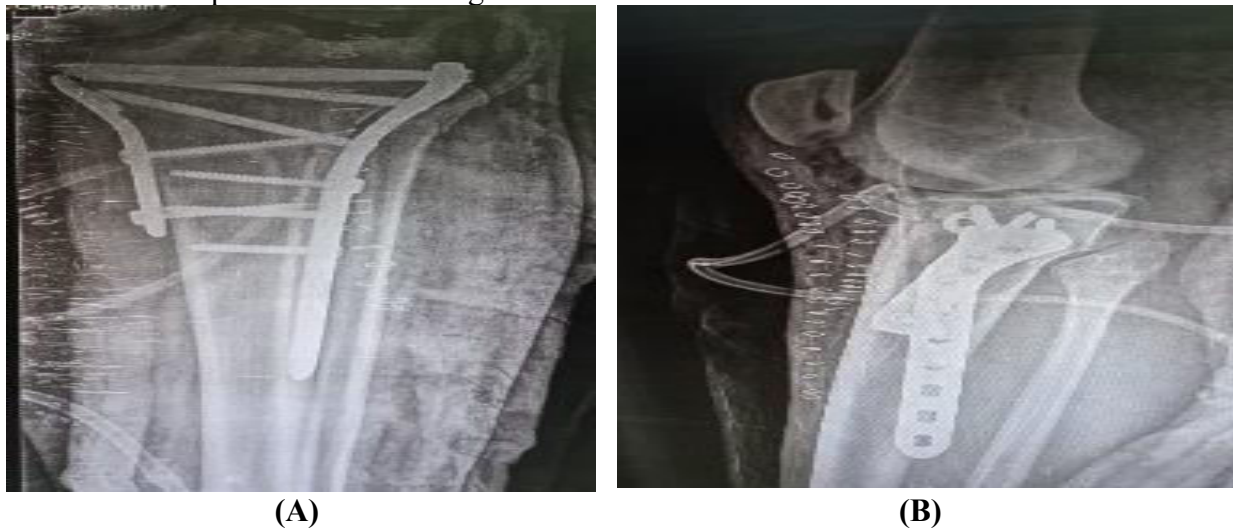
(A) Anteroposterior X-ray view and (B) lateral X-ray view in knee
